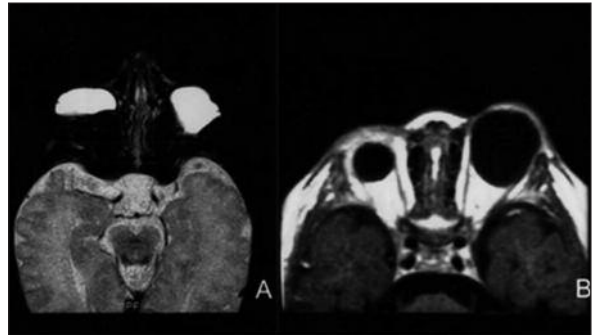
Presence of bilateral cystic eyes with irregular borders on T2 weighted magnetic resonance imaging at the age of 3 days (A). Enlargement of the cystic eye on T1 weighted images at the age of 14 months (B).
